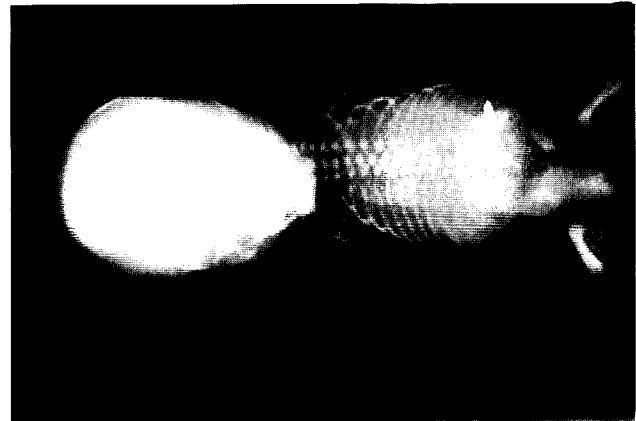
Radiograph with spinal defect.
